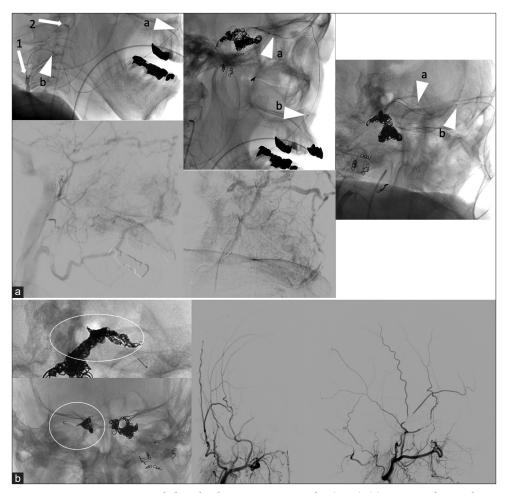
Operative X-ray and digital subtraction angiography (DSA) (a). 7 Fr guiding catheter (arrow 1) was navigated to right internal jugular vein, and 4 Fr diagnostic catheter (arrow 2) was in right external carotid artery. Micro catheter (MC; arrow head a) and distal access catheter (DAC; arrow head b) was navigated to facial vein. MC (arrow head a) was navigated to superior middle cerebral vein superior ophthalmic vein (SOV) through, and DAC (arrow head b) was placed into SOV. DSA shows approach route, facial vein. (b) Coils which were showed in the circle were inserted, and cavernous sinus dural arteriovenous fistula was completely occluded.
